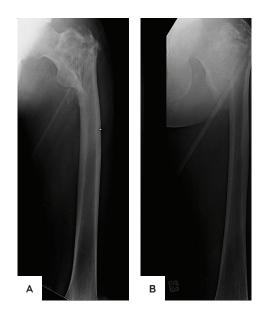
AP radiographs at 1 month (A) and 3 months (B) post-injury of the left hip show fracture site consolidation and development of a sclerotic rim around the lesion while on Denosumab.
